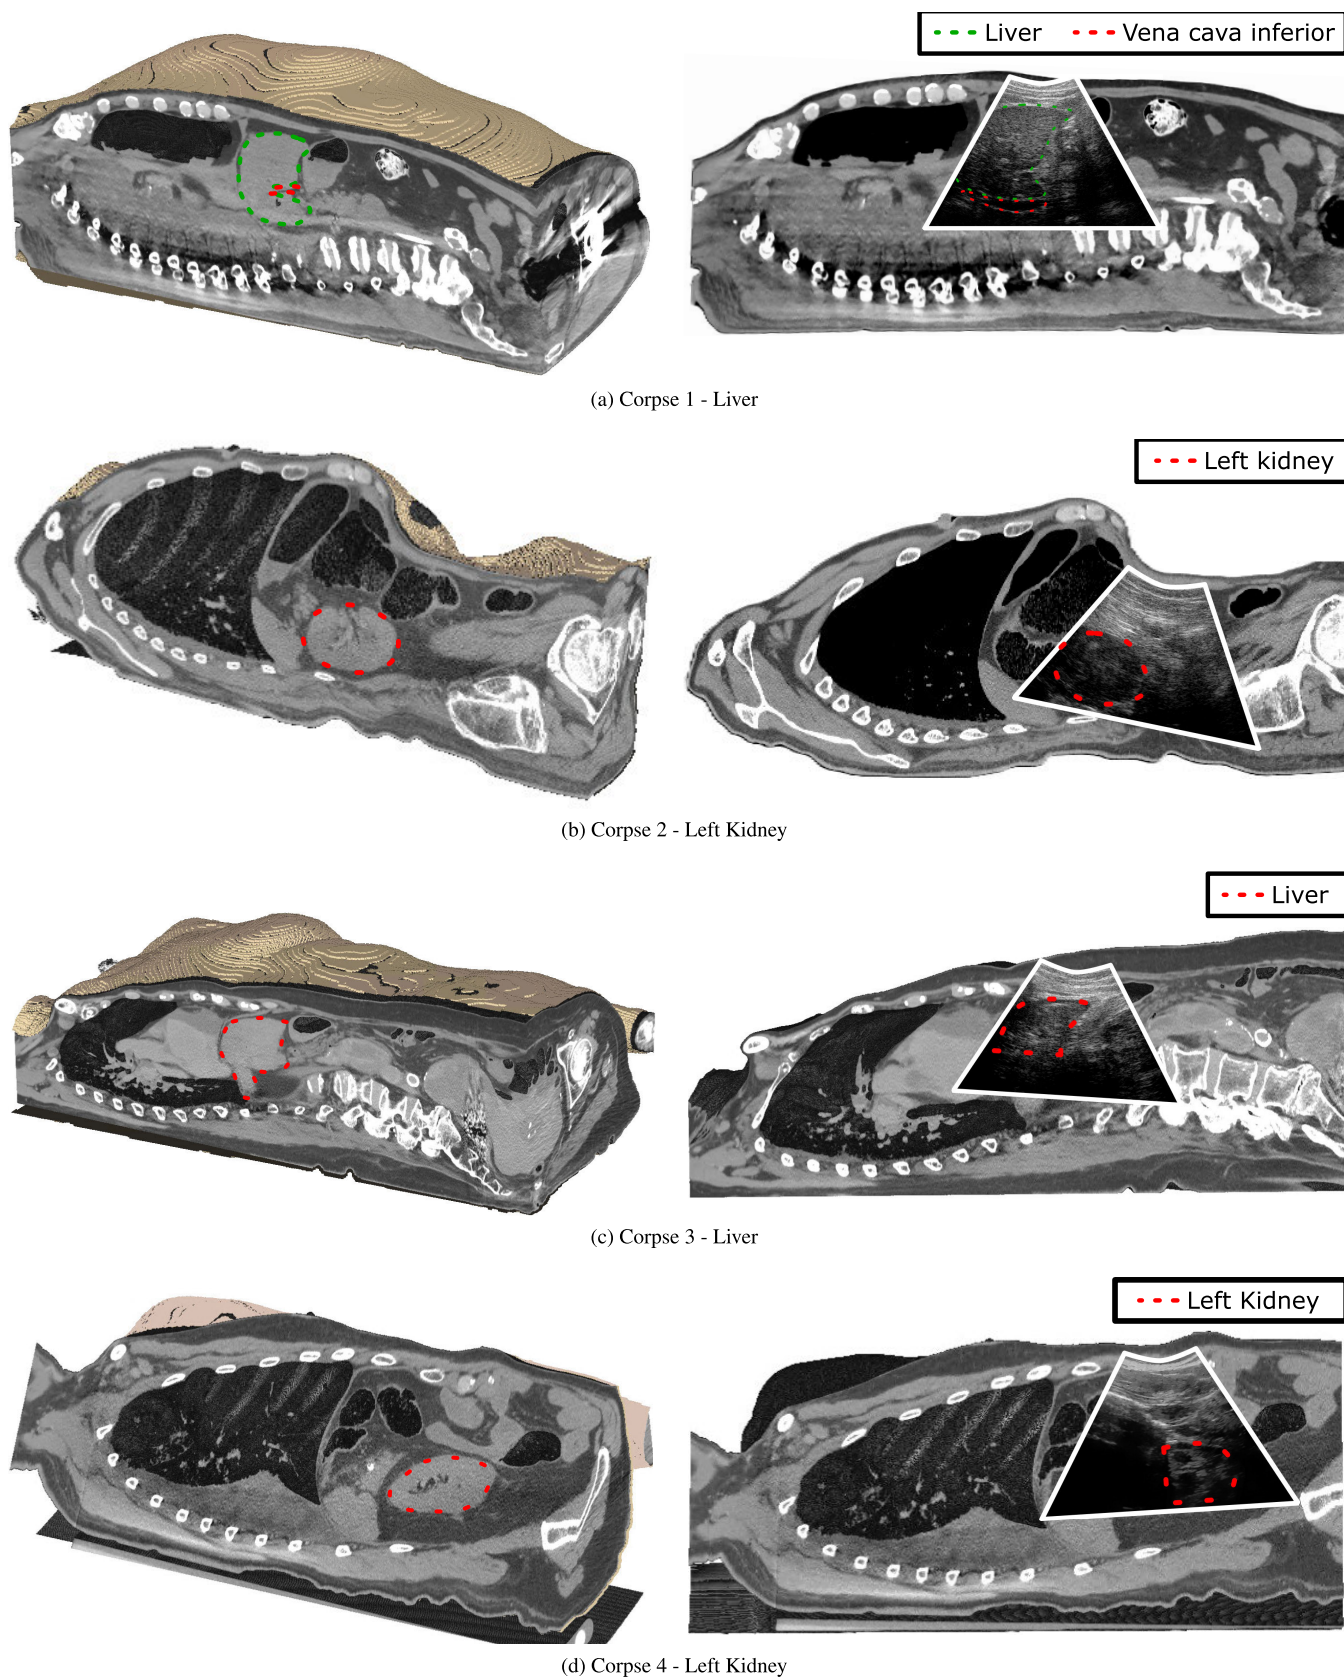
US and CT data acquired in the legal medicine. (Left column) For each corpse, the 3D CT scan is cropped at the plane of a representative US image to visualize the internal anatomy. (Right column) The corresponding 2D view of the CT cross-section along the US imaging plane is shown with the US image overlaid. All modalities are registered in the world frame.
